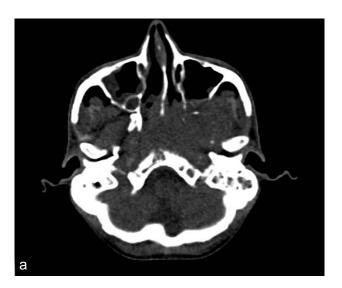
Depict axial PET CT scan images showing a fluorodeoxyglucose (FDG) avid mass lesion arising from the left nasopharyngeal wall and anteriorly extending to involve the fossa of Rosenmuller, infiltrating in the left para-nasopharyngeal region. SUV max of 5.22.
